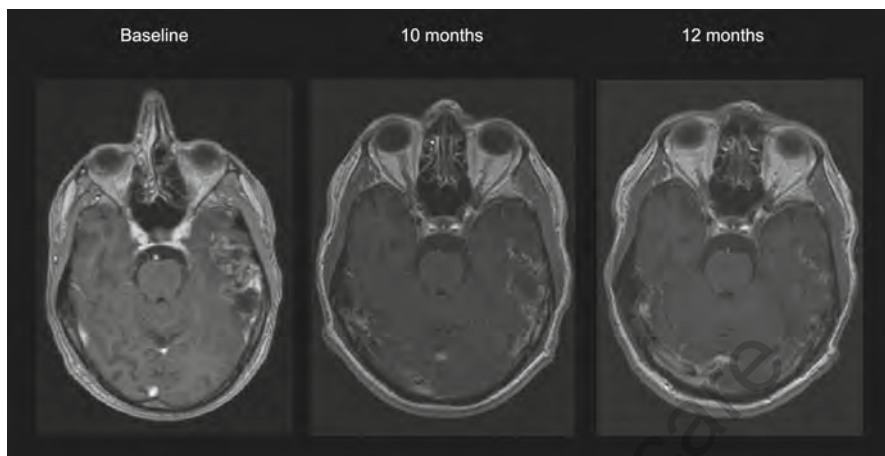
T1-weighted post-contrast MR images of a 51-year-old man with primary GBM which recurred 6 months after chemoradiotherapy with temozolomide. The patient underwent a biopsy of the tumor only without surgical resection. He had a very gradual response, reaching a 50 % reduction in tumor size after 10 months on TTFields. He remained stable for an additional 2 months on treatment. Vymazal et al. Response patterns of recurrent glioblastomas treated with tumor-treating fields, *Semin Oncol.* 41 Suppl 6:S14-S24, 2014. Elsevier
